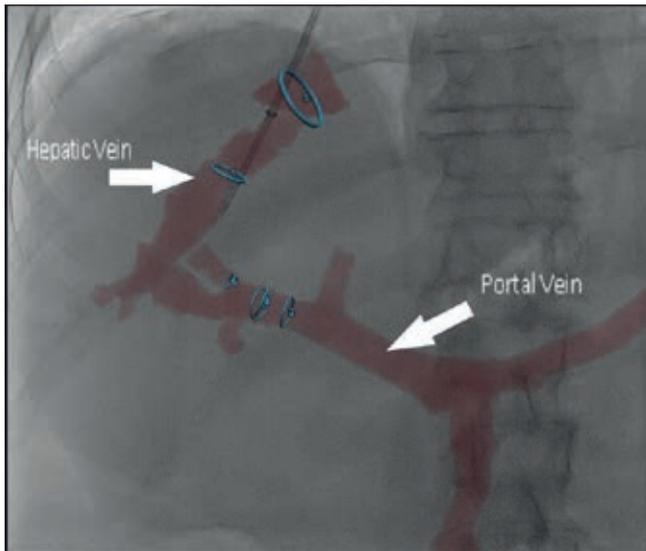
CT guided fusion imaging
